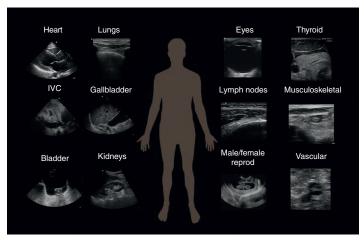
Common Diagnostic Applications of Point-of-Care Ultrasound. IVC, Inferior vena cava.
